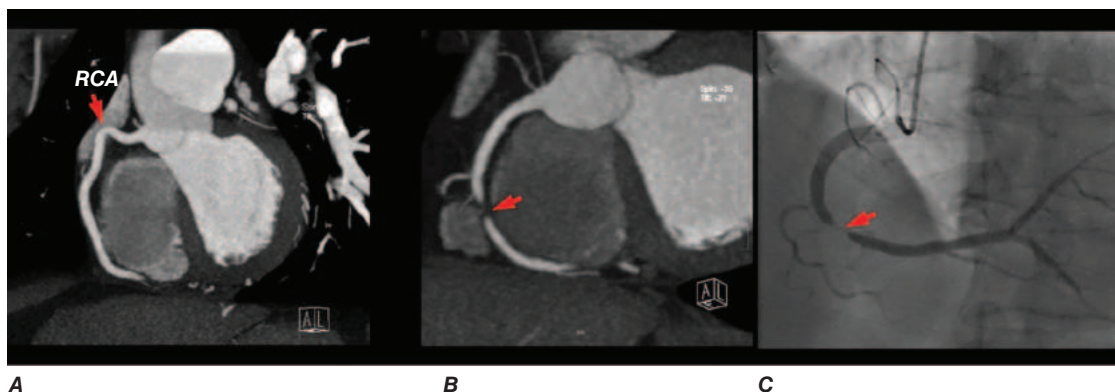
Representative coronary computed tomography angiographic (CTA) images of two patients presenting to the emergency department with chest pain and negative biomarkers. The patient in A had angiographically normal coronary arteries; the panel shows a representative view of the right coronary artery (RCA). B and C show a corresponding significant stenosis in the mid portion of the RCA on both the CTA (B) and invasive angiographic view (C). (Images used with permission from Dr. Quynh Truong, Massachusetts General Hospital, Boston, MA.)
